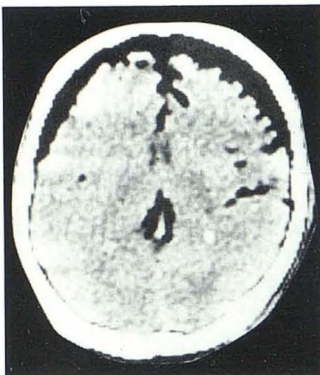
63-year-old man had nonfunctioning pituitary adenoma removed transphenoidally 1 day before. On day of CT study, he suddenly developed an unreactive right pupil and new right field deficit. Unenhanced scan shows
